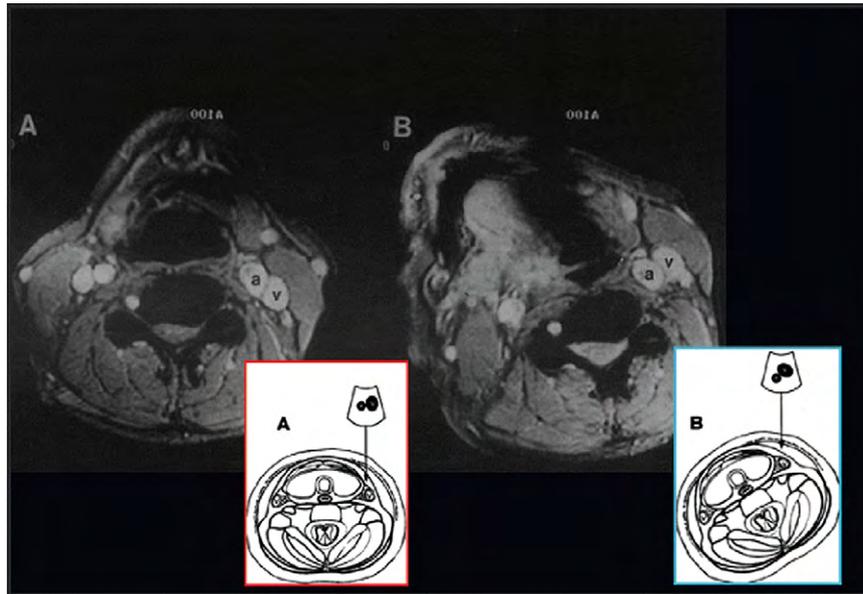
Magnetic resonance imaging of neck anatomy. Contralateral turn of the neck increases the overlap between IJ vein (v) and CA (a). From *Anesthesiology*.²³
